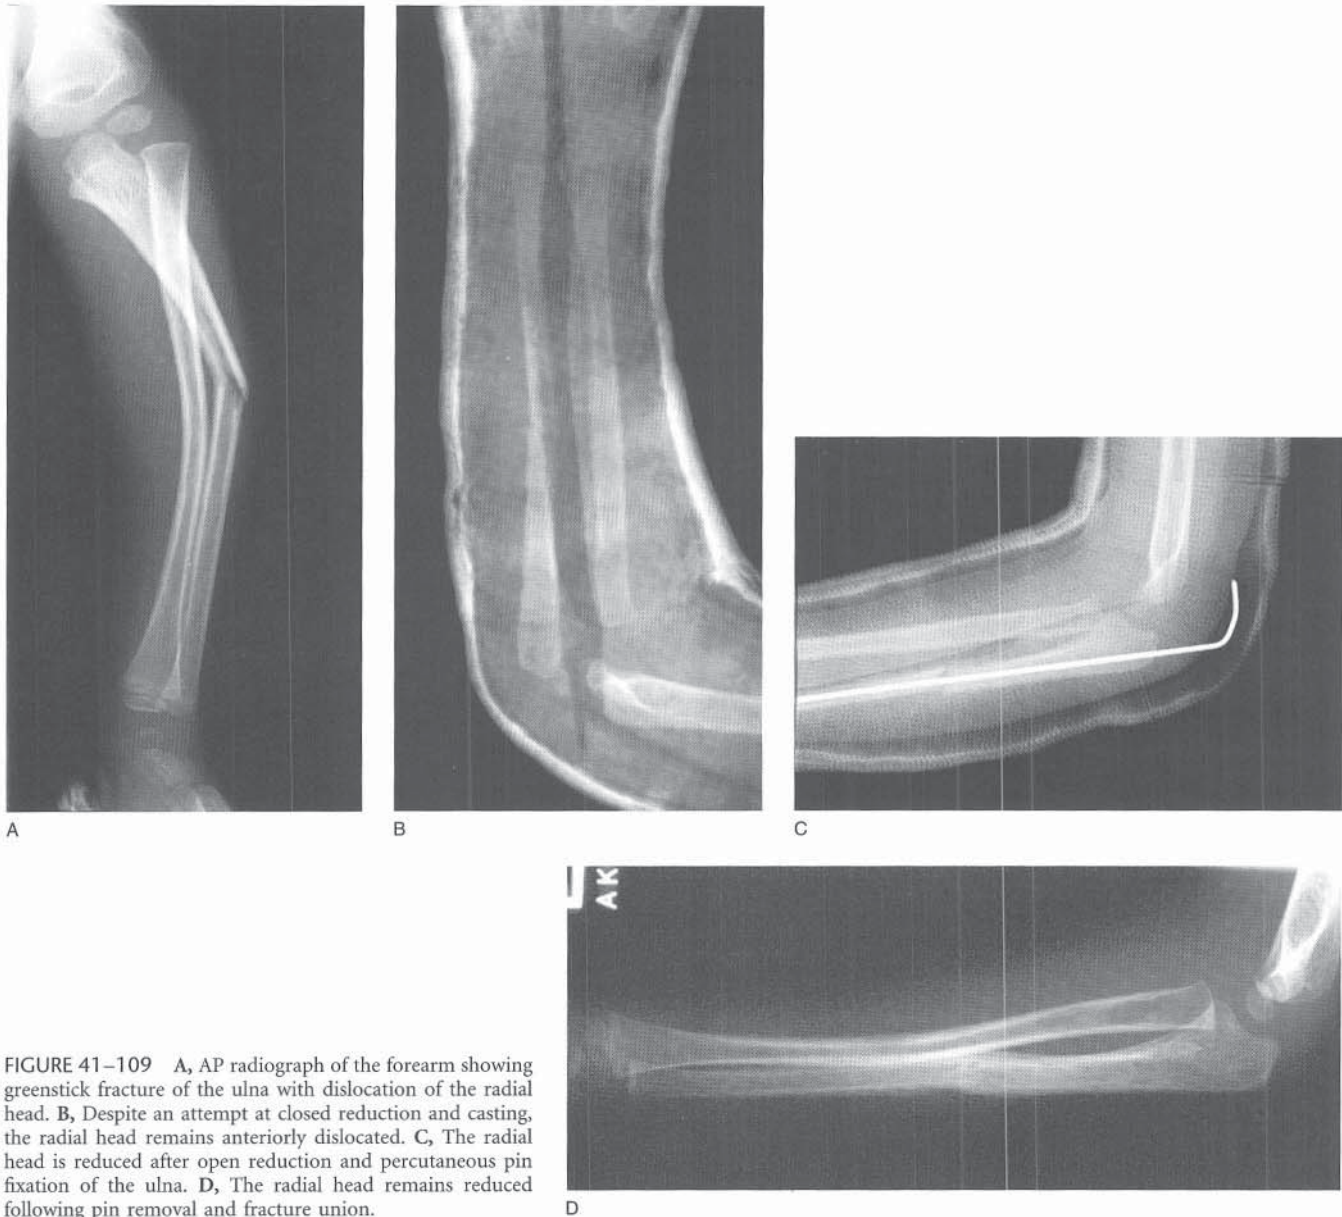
A, AP radiograph of the forearm showing greenstick fracture of the ulna with dislocation of the radial head. B, Despite an attempt at closed reduction and casting, the radial head remains anteriorly dislocated. C, The radial head is reduced after open reduction and percutaneous pin fixation of the ulna. D, The radial head remains reduced following pin removal and fracture union.
